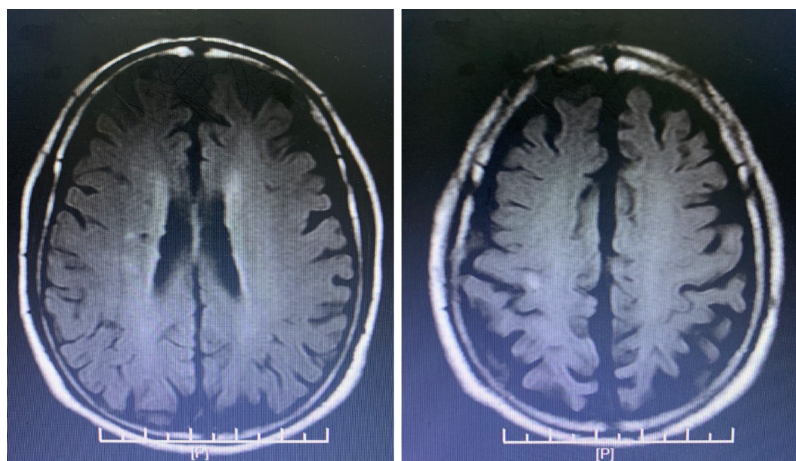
Magnetic resonance imaging showing cerebral infarction.
